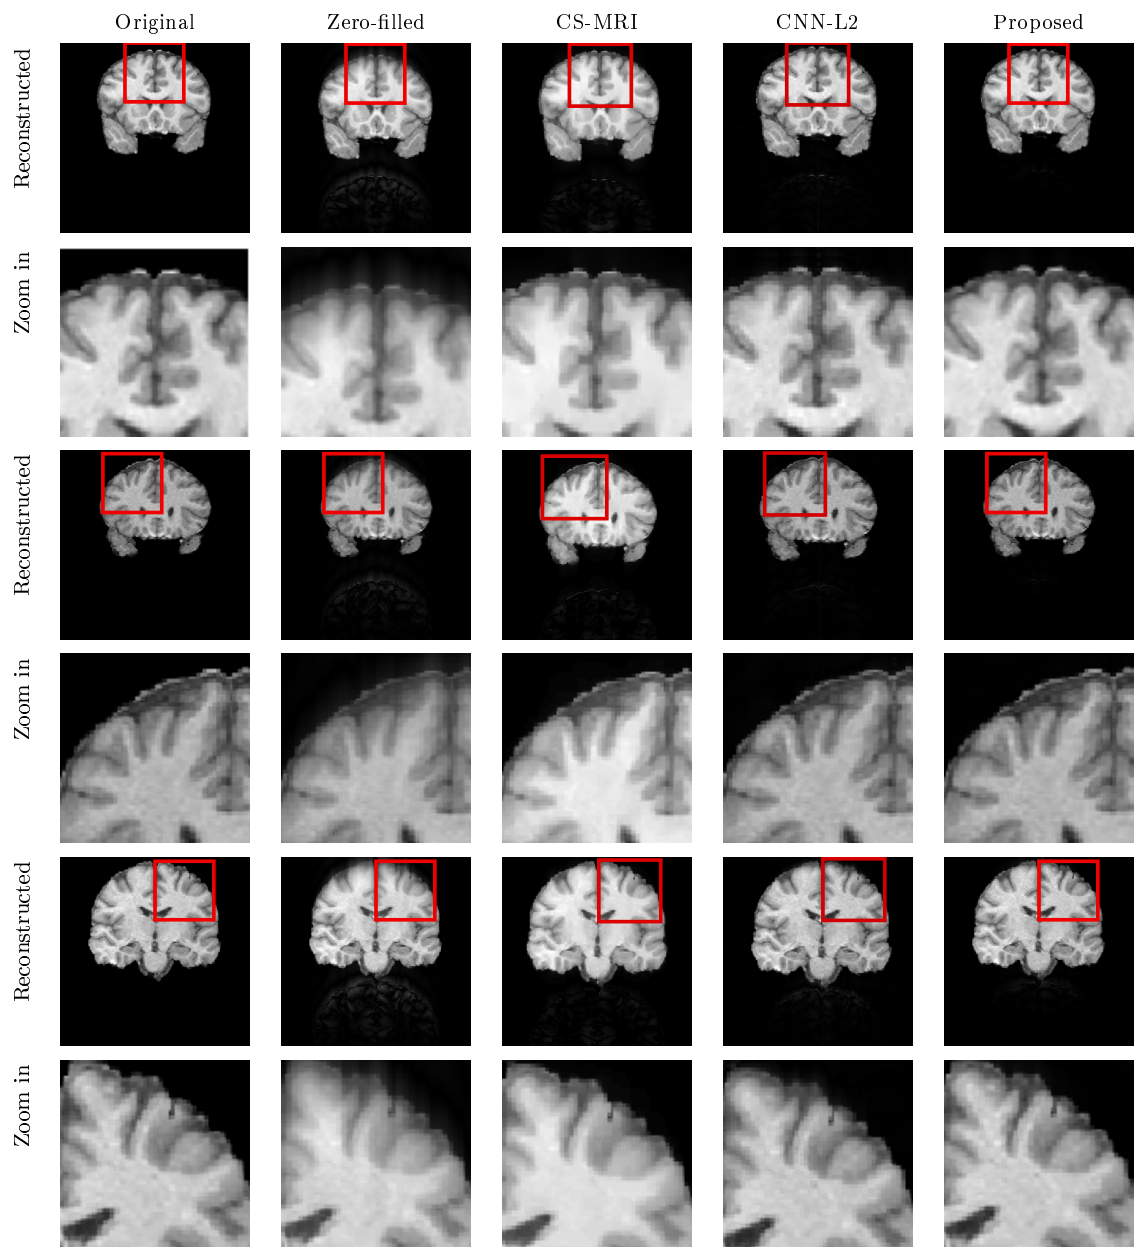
Examples of reconstructed MR images from under-sampled k-space.
